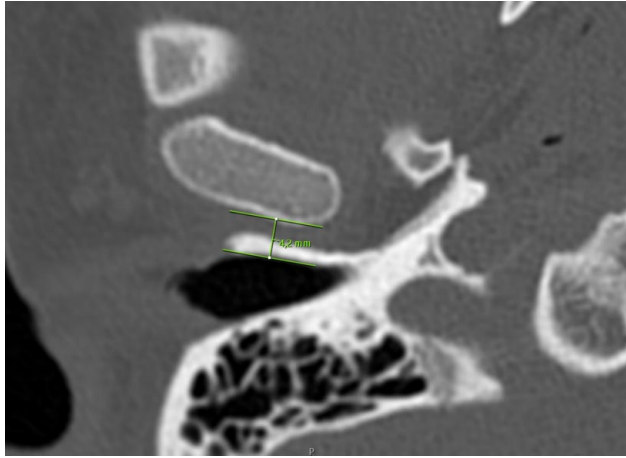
Temporal CT image of a 23-year-old man (Right Total WTT)
